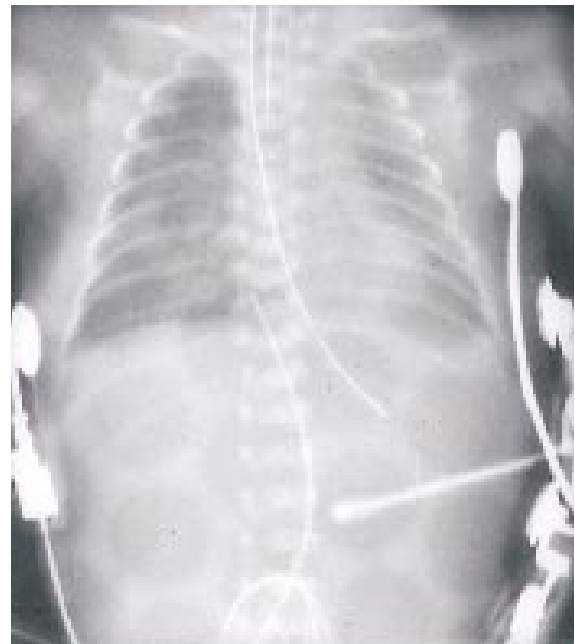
Radiograph of chest and abdomen showing artifactual shadows from placement of the infant on an air mattress. It is important to be aware of these possible artifacts when reviewing radiographic films.
